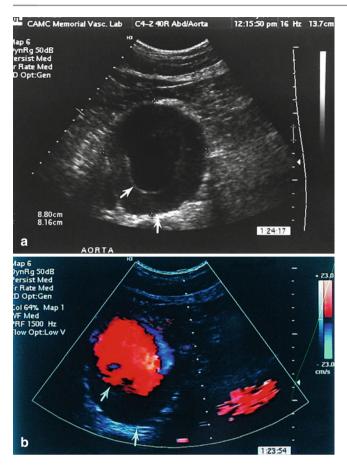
(a) A duplex ultrasound image of an abdominal aortic aneurysm measuring 8.8 cm in AP diameter and 8.16 cm in transverse diameter. Please notice the presence of thrombus between the inside and outside *arrows*. (b) A color duplex ultrasound image of the same abdominal aortic aneurysm showing the lumen as noted in *color* and the thrombus as indicated by *arrows*
